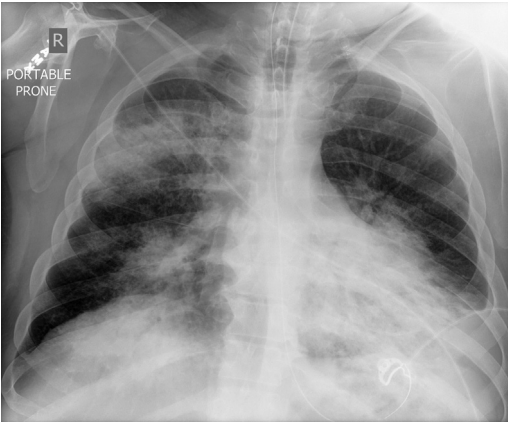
Chest radiograph in a patient with multifocal consolidation and small left parapneumonic effusion secondary to pneumococcal (*Streptococcus pneumoniae*) pneumonia. Parapneumonic effusions are present in up to one-third of patients with pneumococcal pneumonia.
